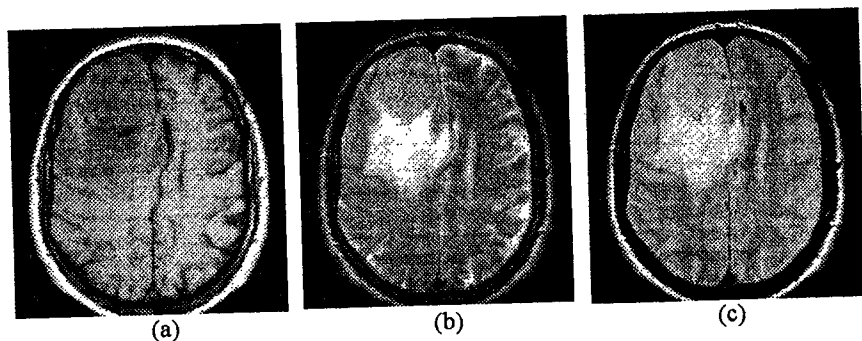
T1 (a), T2 (b) and PD (c) MRI images with meningioma
